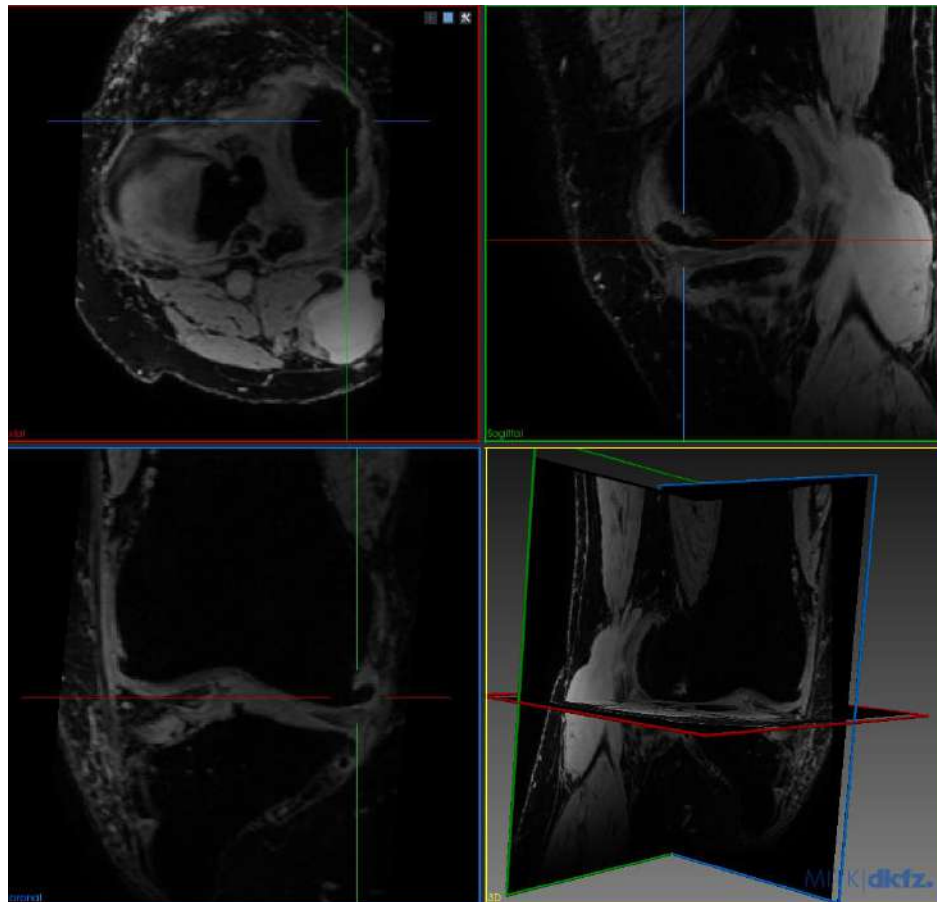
MRI of advanced medial osteoarthritis with visible osteophytes. Cross-section images from the axial, sagittal and frontal plane.
